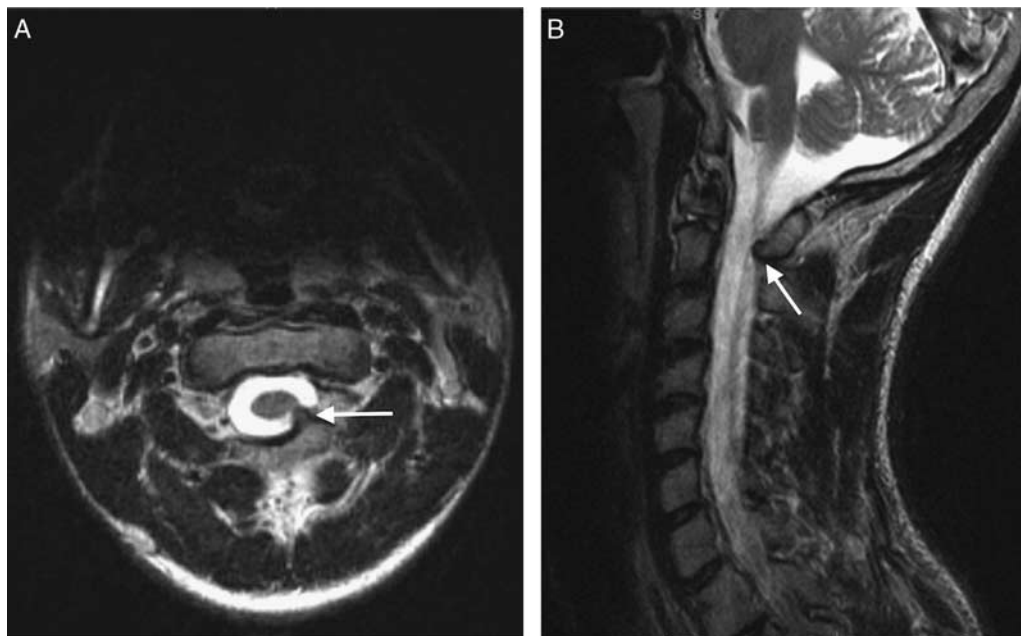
A 14-year-old child with an intracanal osteochondroma of the C2 lamina (arrows) visible on axial (A) and sagittal (B) T2-weighted noncontrast magnetic resonance imaging. This child was also found to have a pelvic osteochondroma and 2 rib osteochondromas.
